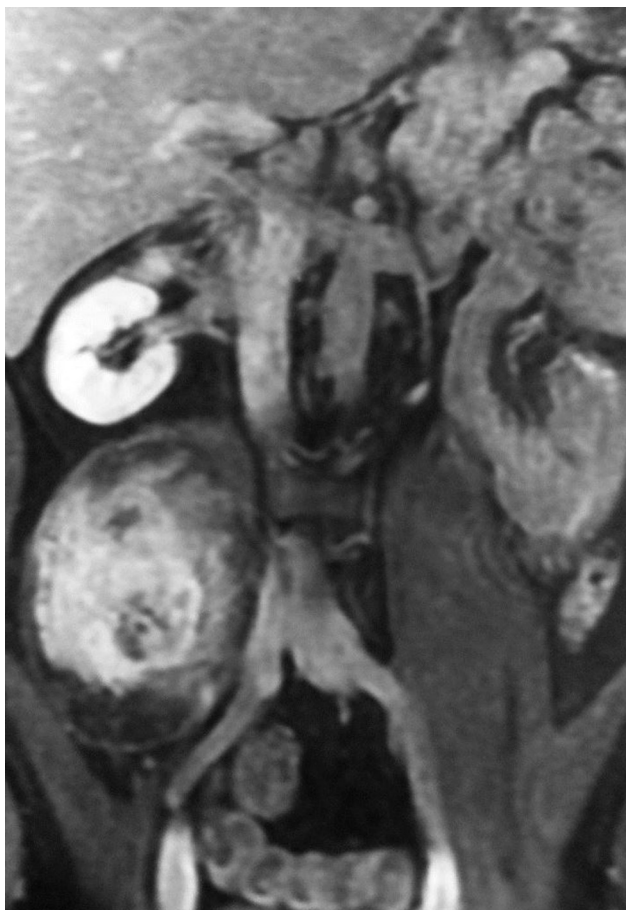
Frontal angio-magnetic resonance imaging scans showing the right paravertebral neoplasm in the retroperitoneum space.
